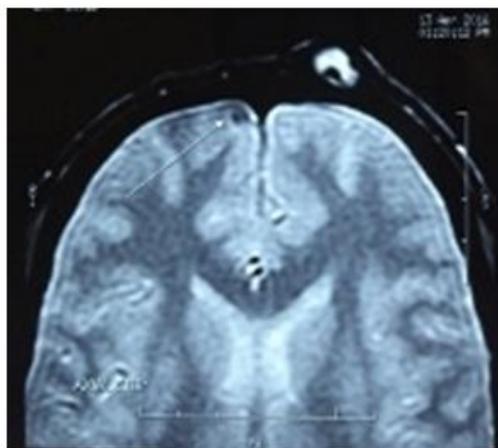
T1-weighted MRI brain showing target-like lesion in left frontal subcutaneous region. Small hypodense mass also seen in right frontal lobe (marked by arrow)
